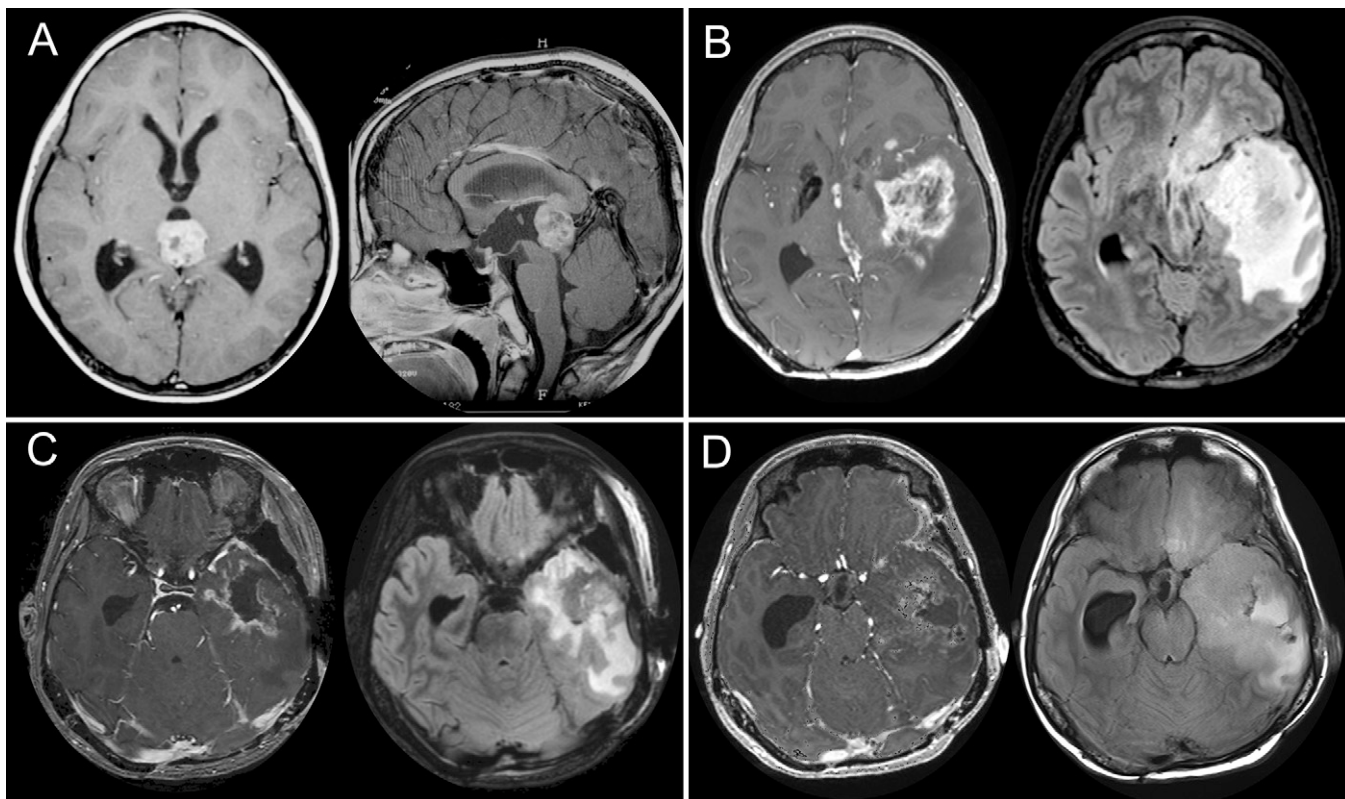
Case 1. A: Axial and sagittal Gd-enhanced T1-weighted imaging (T1WI) on admission. B: Axial Gd-enhanced T1WI and fluid-attenuated inversion recovery (FLAIR) image at the development of radiation-induced glioblastoma. C: Axial Gd-enhanced T1WI and FLAIR images after removal of the glioblastoma. D: Axial Gd-enhanced T1WI and FLAIR image at the recurrence of the glioblastoma. Gd-enhancing bifocal GCTs are shown at the pineal region and pituitary stalk (A). Radiation-induced glioblastoma developed as a Gd-enhancing tumor in the left frontotemporal region in the previous radiation therapy field with marked peritumoral edema and in the third ventricle as disseminated lesions (B). Gd-enhancing tumor was partially removed, and peritumoral edema decreased (C). After 2 months, tumor and surrounding edema showed progression (D).
